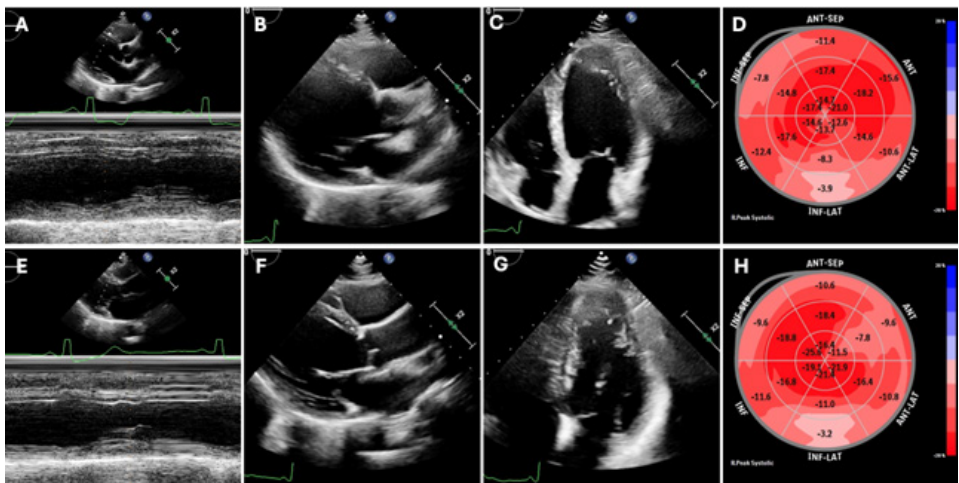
Echocardiography of the patient before (A–D) and after (E–H) radiofrequency ablation of premature ventricular contractions. The left ventricular end-diastolic diameter and ejection fraction were 60.5 mm and 43.7%, respectively (A), and showed no significant changes after ablation, with values of 60.3 mm and 43.4%, respectively (E). The parasternal long-axis view (B and F) and apical four-chamber view (C and G) demonstrated left ventricular dilation with prominent trabeculations in the apical and lateral walls. Speckle-tracking echocardiography before (D) and after (H) ablation revealed no significant change in global longitudinal strain, with values of –13.6% and –13.5%, respectively.
